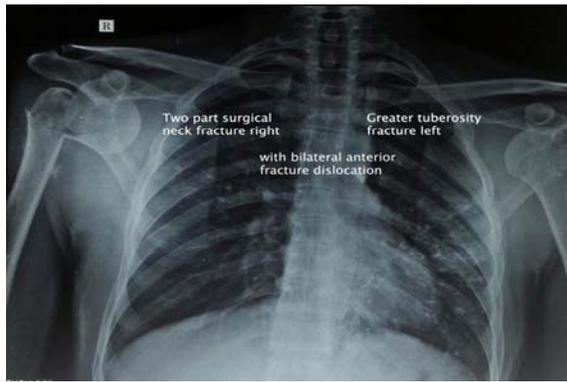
Radiograph showing bilateral fracture dislocation of shoulder joint
